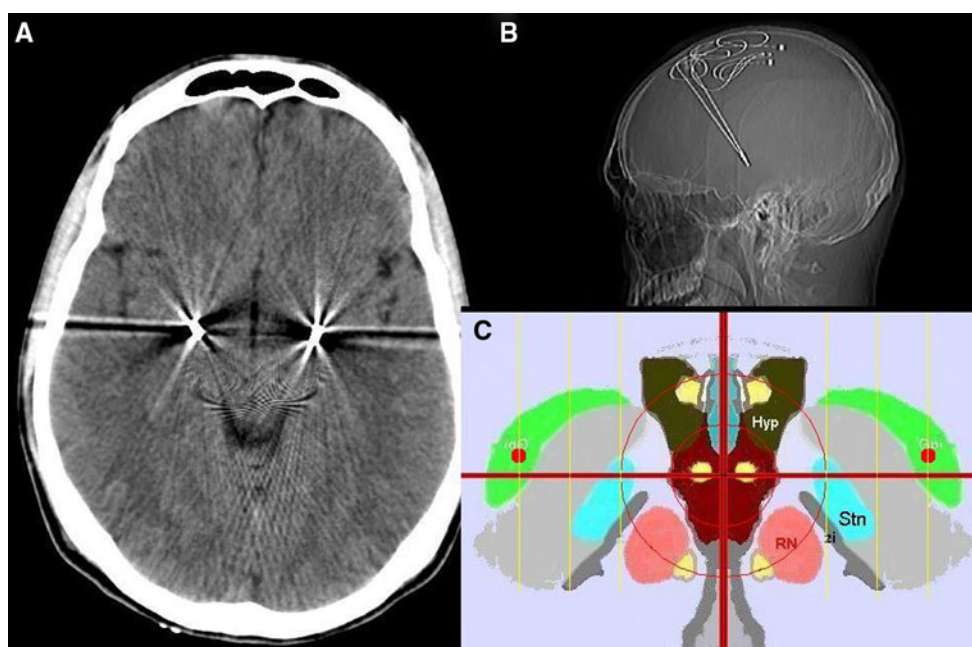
a CT scan, axial: bilateral correct placement of DBS electrodes in the GPI; b skull Rx: DBS electrodes after implantation and before IPGs positioning in the subclavian regions; c images from
